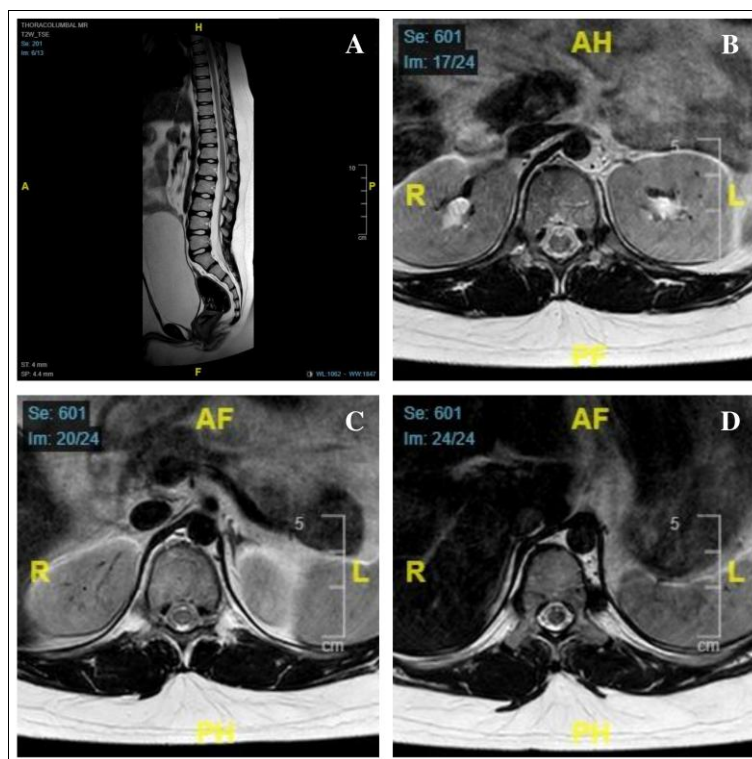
(A) Spinal cord swelling and slight hyperintensity in sagittal T2WI thoracolumbal spine MRI with axial view of T10 (B), T11 (C) and T12 (D)
